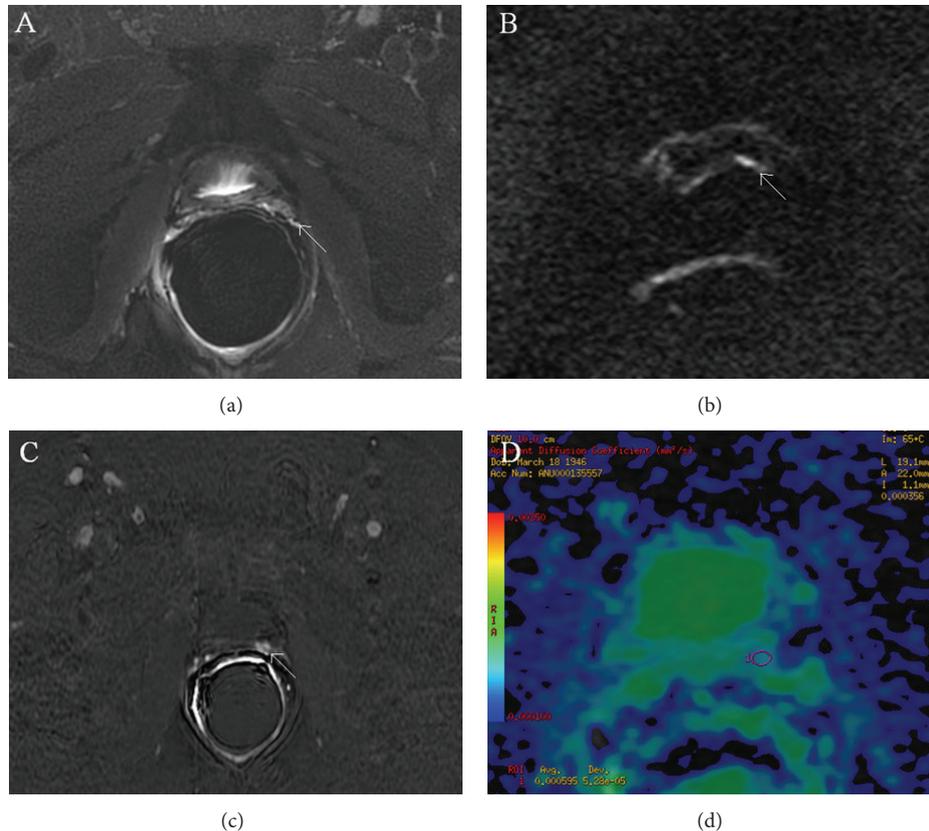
Multiparametric-MR images of a 71-year-old man with prostate-specific antigen progression (PSA serum value 0.6 ng/mL) after radical retropubic prostatectomy, with suspected local recurrence. (a) Axial T2-weighted fat saturated fast spin-echo image shows, on the zone previously occupied by the left seminal vesicle, a hyperintense solid nodular tissue (white arrow) compared to pelvic muscles, of about 7 mm in size. (b) Axial DWI image with a b value of 1000 s/mm^2 shows a focal area of restricted diffusion (white arrow) corresponding to the solid nodular tissue detected on T2-weighted image. (c) Axial Gradient-echo T1-weighted subtracted image showing a remarkable enhancement of the pathological tissue. All these findings are consistent with locoregional relapse. (d) ADC map reconstructed from images obtained at b values of 0, 500, and 1000, where the ROI was plotted for the measurement of ADC values in order to assess the aggressiveness of the nodule.
